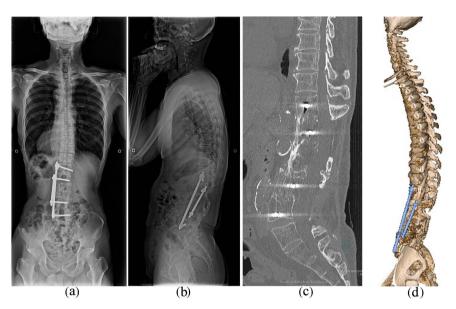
Plain X-ray radiographs and CT at 32 years after surgery. (a) Full-length postero-anterior view. (b) Lateral view showing pelvic incidence—lumbar lordosis of 5°. (c) Sagittal reconstruction CT showed solid fusion. (d) Lateral view of 3D-CT reconstruction.
